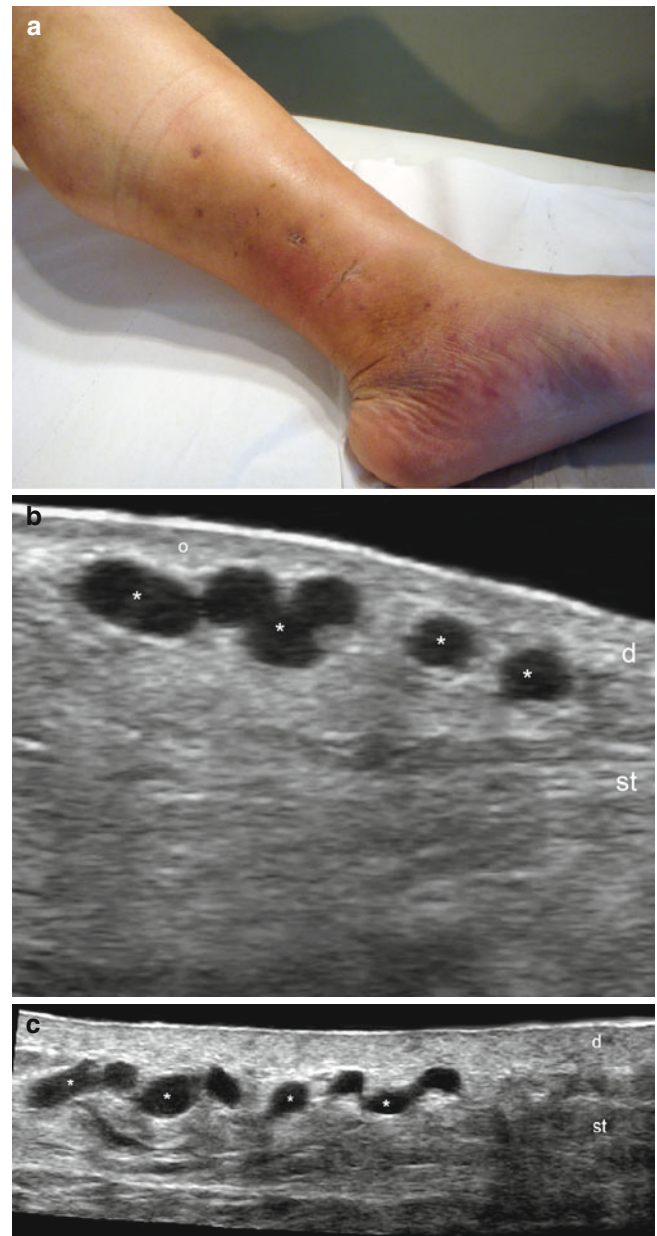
(a–c) Chronic venous insufficiency. (a) Clinical image shows swelling and light pigmentation of the medial aspect of the leg. (b) Gray scale ultrasound image (longitudinal view) shows dilated and tortuous anechoic venous vessels (*) in the upper subcutaneous tissue. There is decreased echogenicity of the dermis (*, *d*) and increased echogenicity of the subcutaneous tissue. (c) Gray scale ultrasound image (longitudinal extended field of view) demonstrates the wide extension of the dilated and tortuous subcutaneous venous tracts (*). *Abbreviations:* *d* dermis, *st* subcutaneous tissue
